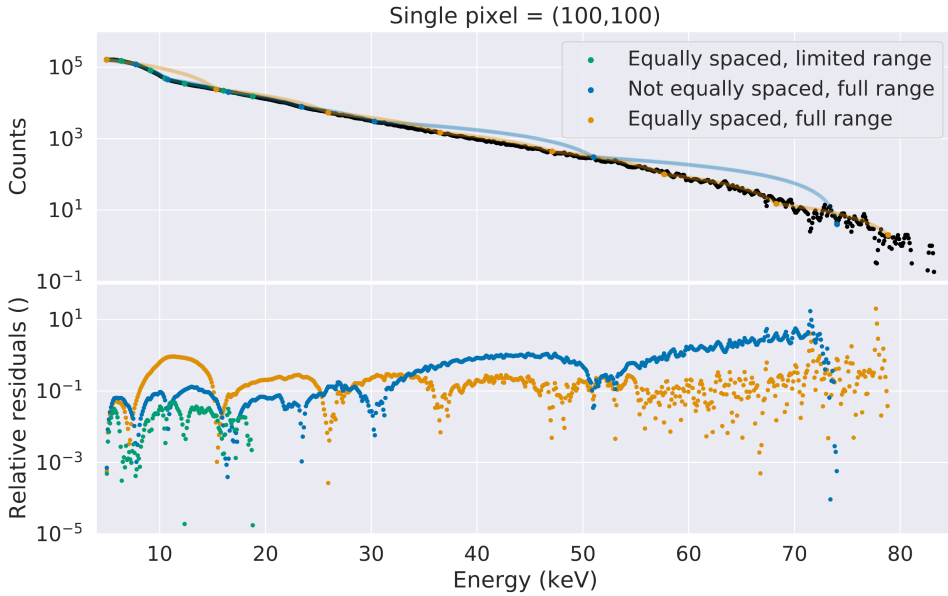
The black line is the counts as a function of energy for a high energy resolution scan for a single arbitrary pixel ($x=100, y=100$). Three approaches are presented for ECI in terms of threshold spacing and their respective relative residuals as shown in the legend. A Si detector was used with a x-ray tube voltage of 90 kVp and only air (flat-field) was measured.
